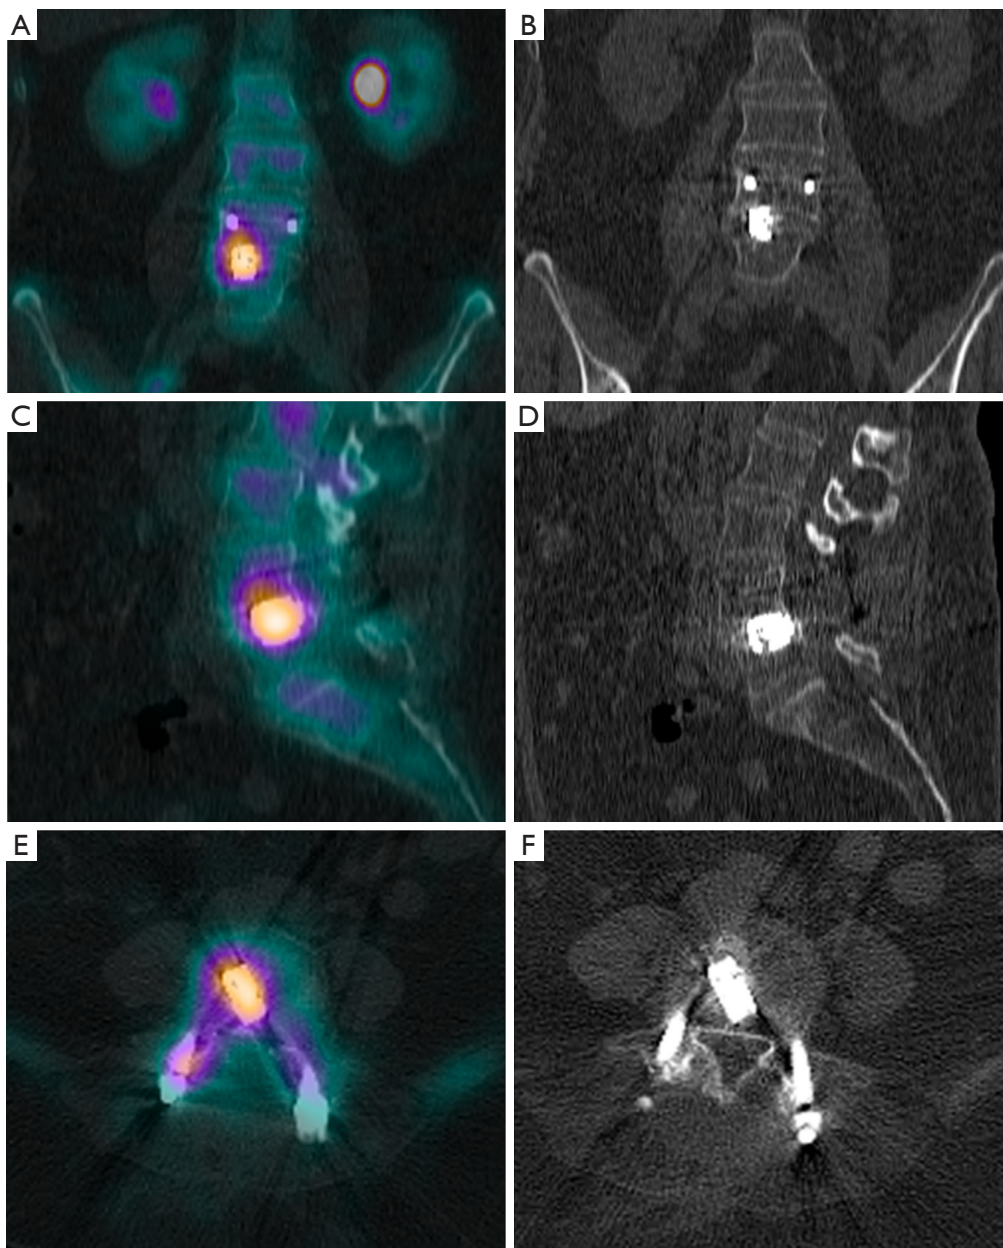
A 74-year-old female suffered L4/5 clinical subsidence secondary to intraoperative endplate (superior and inferior) fractures from overexpansion of cage: (A) coronal SPECT-CT scan; (B) coronal CT scan; (C) sagittal SPECT-CT scan; (D) sagittal CT scan; (E) axial SPECT-CT scan; and (F) axial CT scan. SPECT-CT, single photon emission computed tomography-computed tomography; CT, computed tomography.
